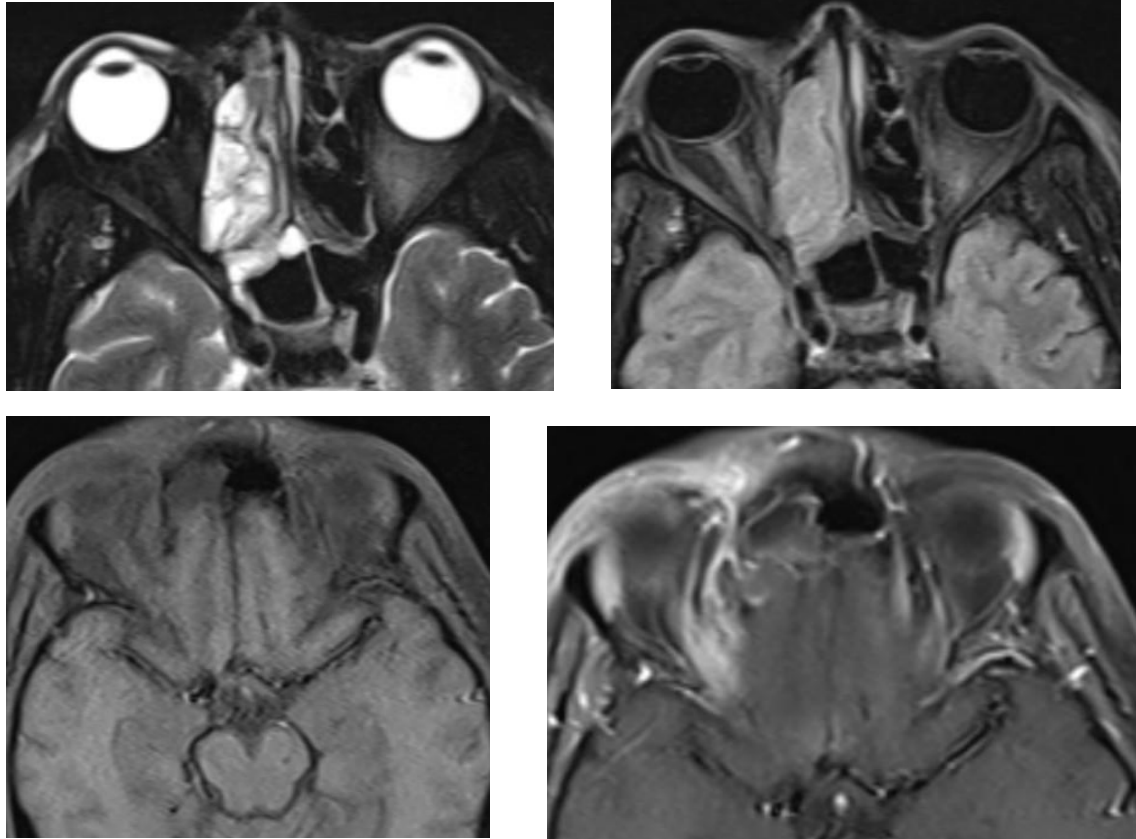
Orbital disease in ROCM Axial T2FS(a),FLAIR(b),T1FS pre contrast(c),T1FS post contrast (d) showing right pre septal involvement of orbit in orbital mucor
